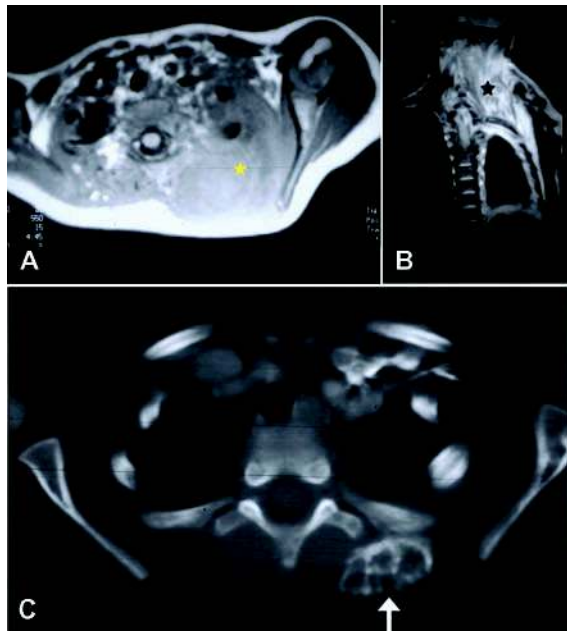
Fibrodysplasia ossificans progressiva developing in a young patient. Axial T1-weighted (A) and coronal T2-weighted (B) magnetic resonance images show extensive infiltration of the left neck by a large mass (*) that has high signal intensity on T2-weighting. Initial CT and radiograph (not shown) revealed no significant calcification, but subsequent CT several months (C) later demonstrated extensive ossification, most prominent peripherally (arrow).
